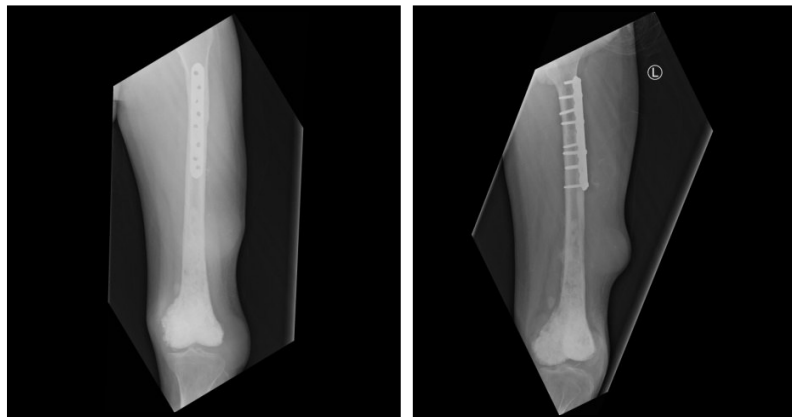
Radiographic evaluation of the AnteroPosterior and Lateral femur 6 months post ECI
